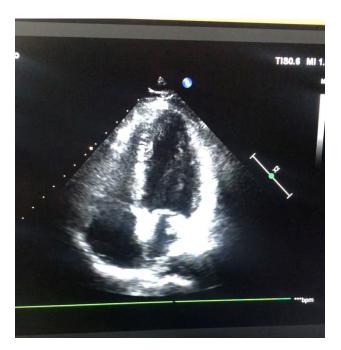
Echocardiography on fourth year of follow up
